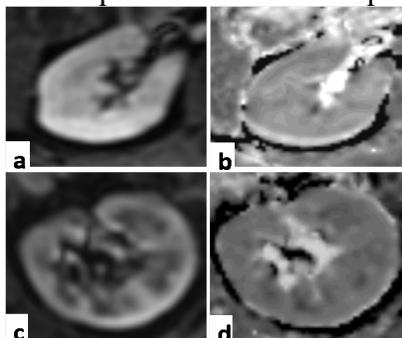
Comparisons of DWI images in patients (a) and (b), and healthy volunteers (c) and (d).
